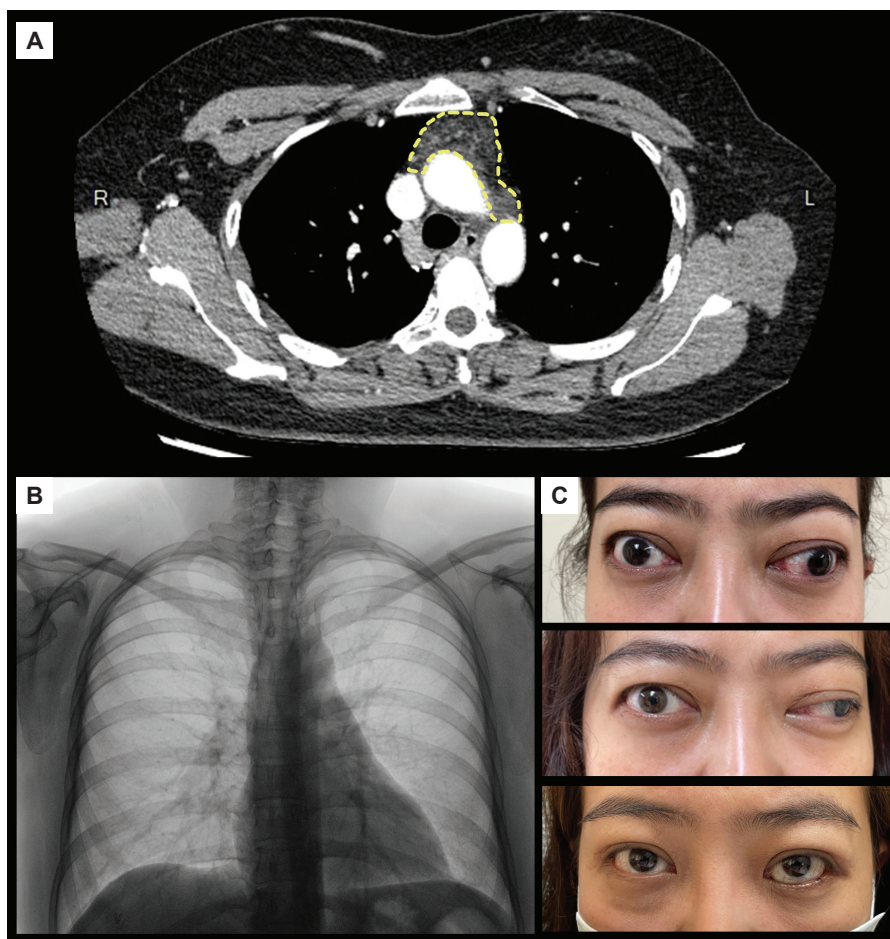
(A) Computed tomography images demonstrated a 10 × 9 × 1.6 cm thymic enlargement (thymic hyperplasia outline as shown in Figure 1A). (B) Chest X-ray at the time of thyroidectomy revealed no widening mediastinum (the brightness of the image is adjusted to enhance visibility). (C) Clinical course of severe thyroid eye disease from the initial presentation (18 months prior to the diagnosis of myasthenia gravis) which demonstrated inflamed bulging of both eyes and strabismus at left eye, new-onset left eye ptosis at the time of myasthenia gravis diagnosis, and after multiple surgical procedures including decompression surgery followed by strabismus surgeries.
